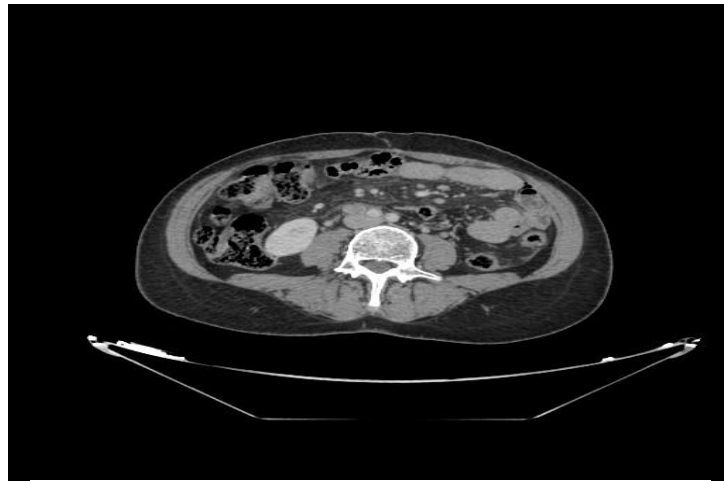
Abdominal stage CT scan showing peritoneal carcinoma.
